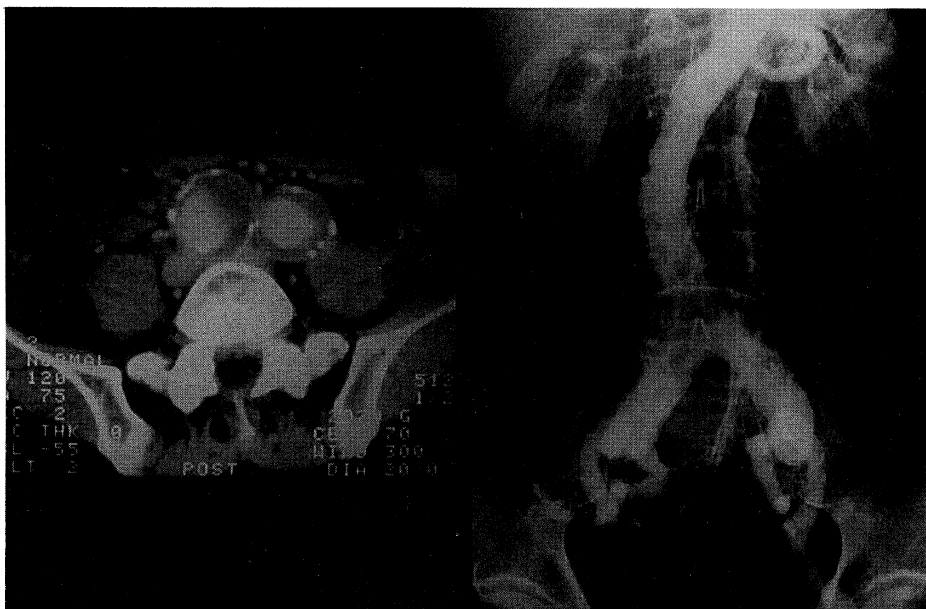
Left: Enhanced abdominal CT scan shows right and left common iliac artery aneurysms. Right: Preoperative arteriography shows right and left common iliac artery aneurysms.
